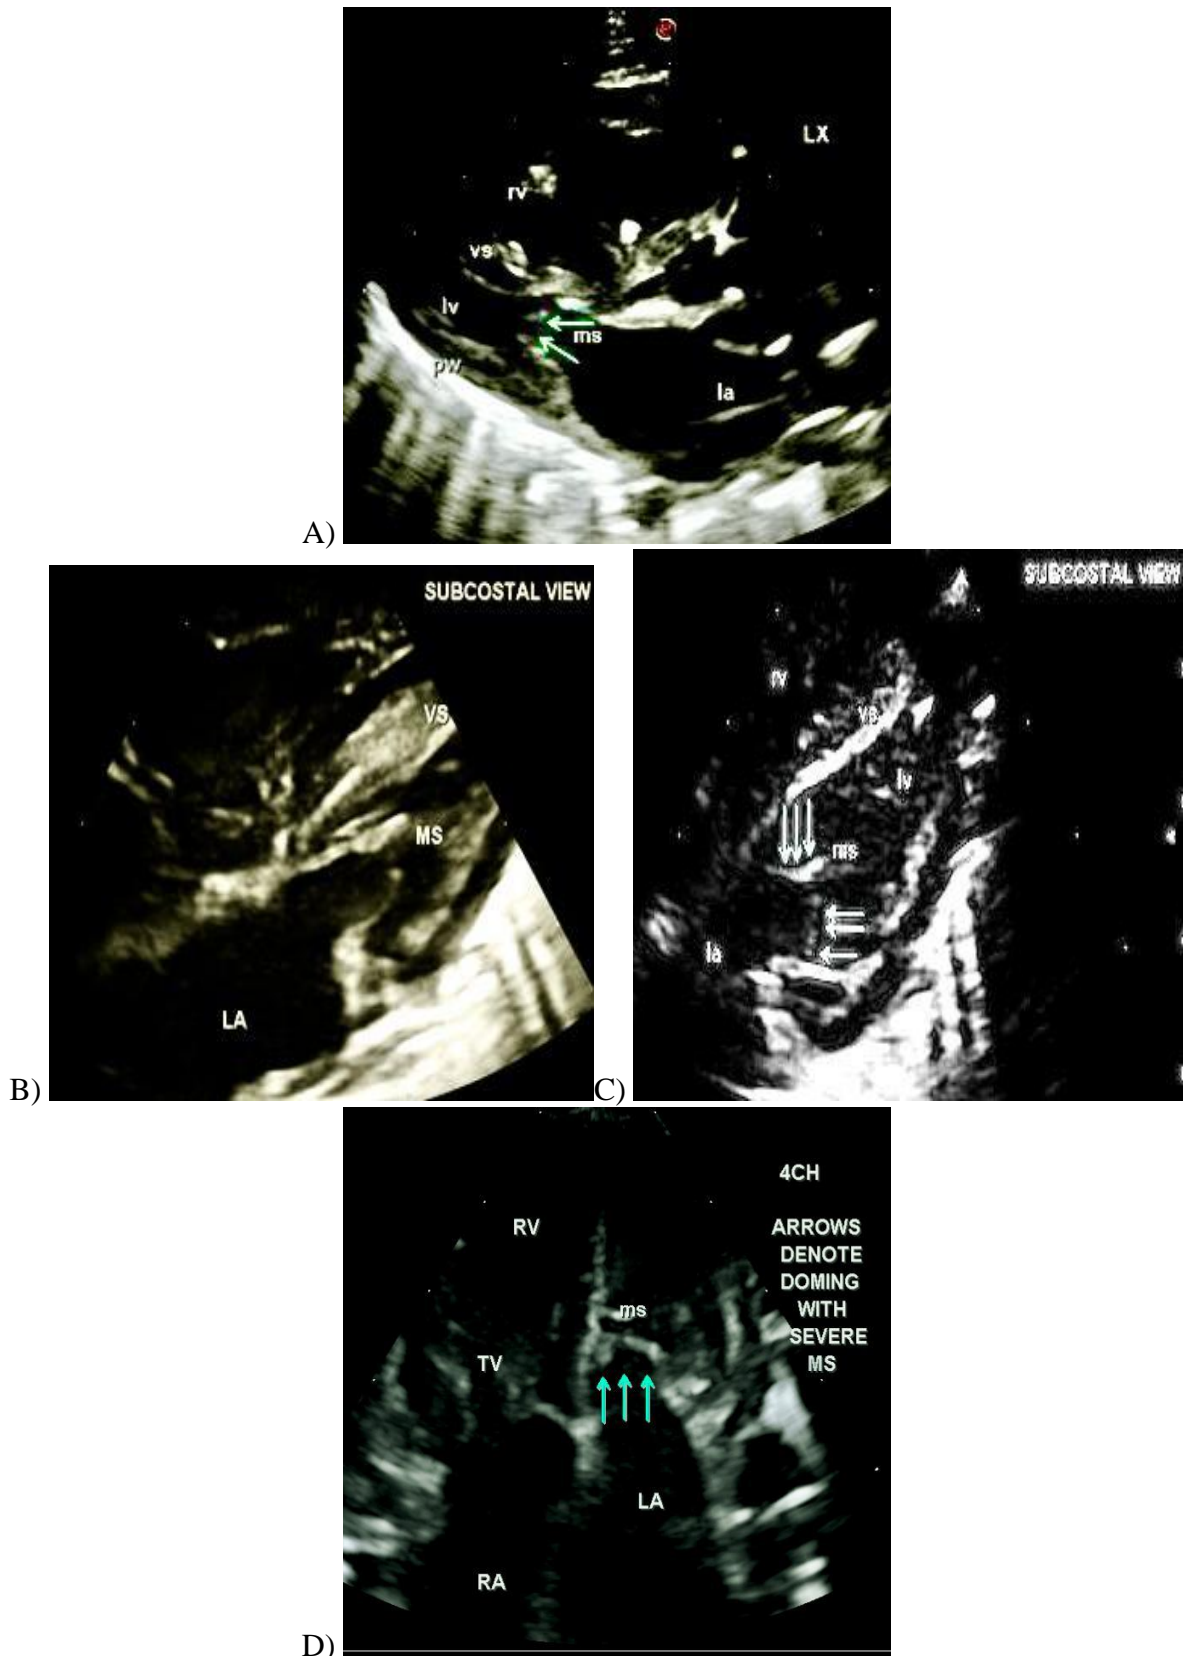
Congenital mitral stenosis. A) Parasternal long axis view is showing domed and severely stenotic mitral valve. B) In the subcostal view a typical congenital mitral stenosis is identified. C) Marked restriction of mobility of anterior and posterior mitral leaflet was observed (arrows denote the non-mobility of mitral valve).D) In the apical 4CH view a severely stenotic and domed mitral valve is detected.
